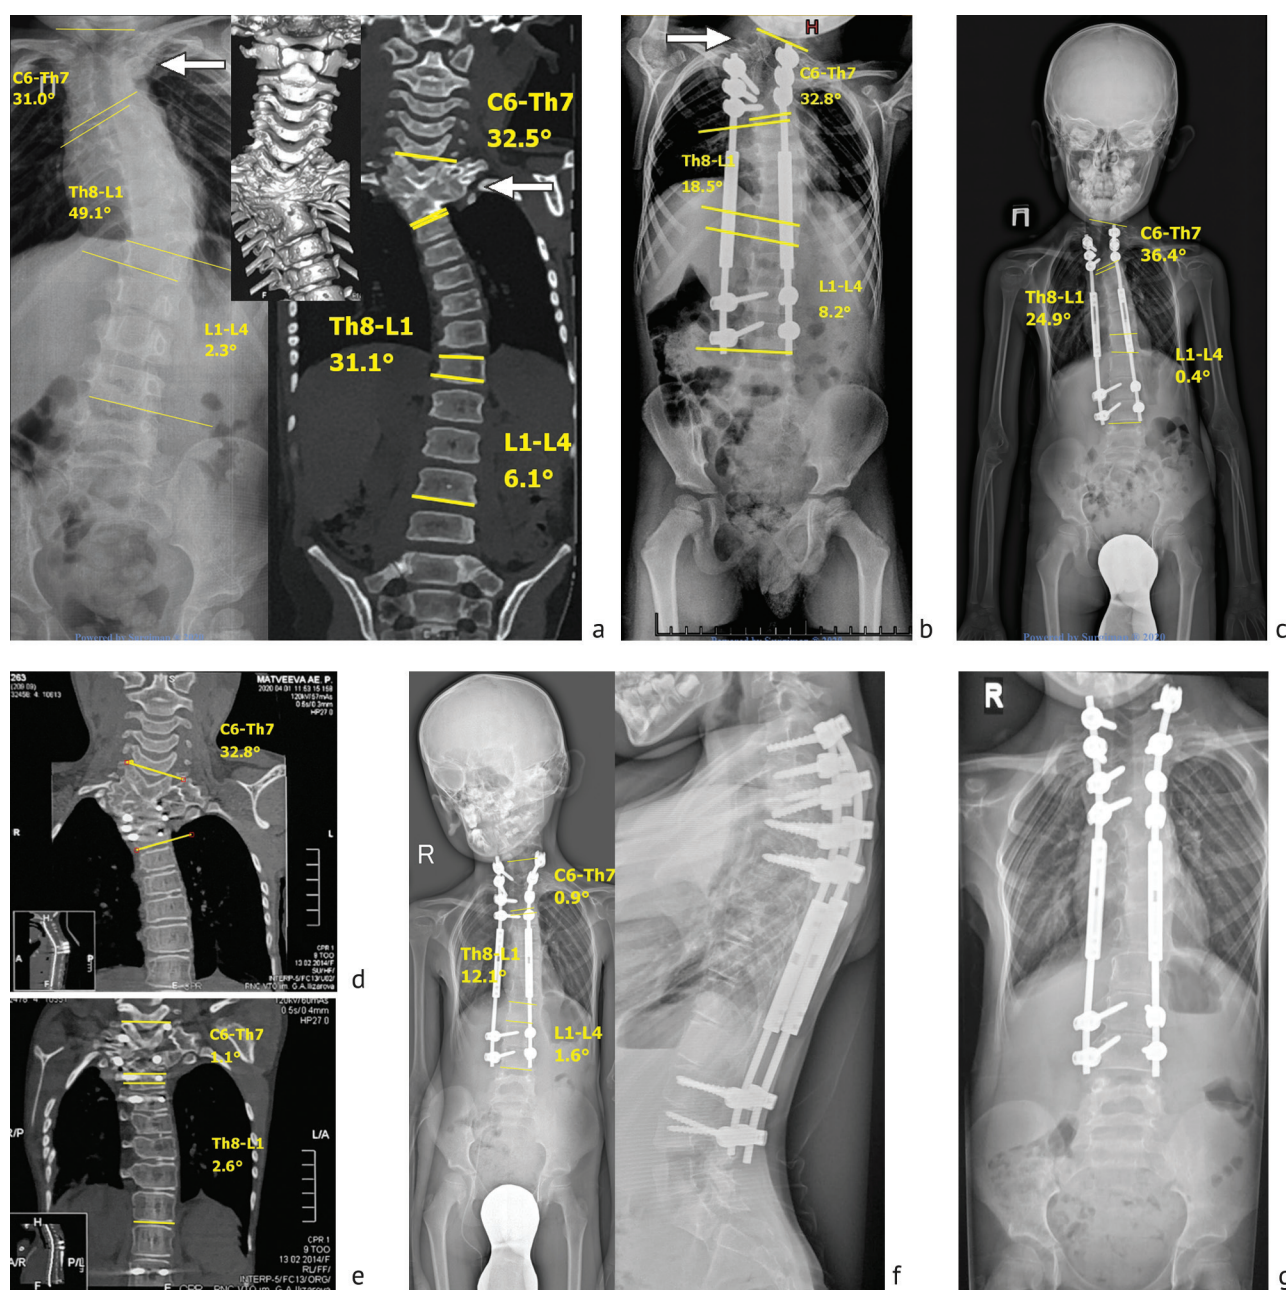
Radiographs and CT scans of a girl aged 3 years 2 months diagnosed with scoliosis of the thoracic spine due to multiple anomalies and segmentation of the vertebrae
